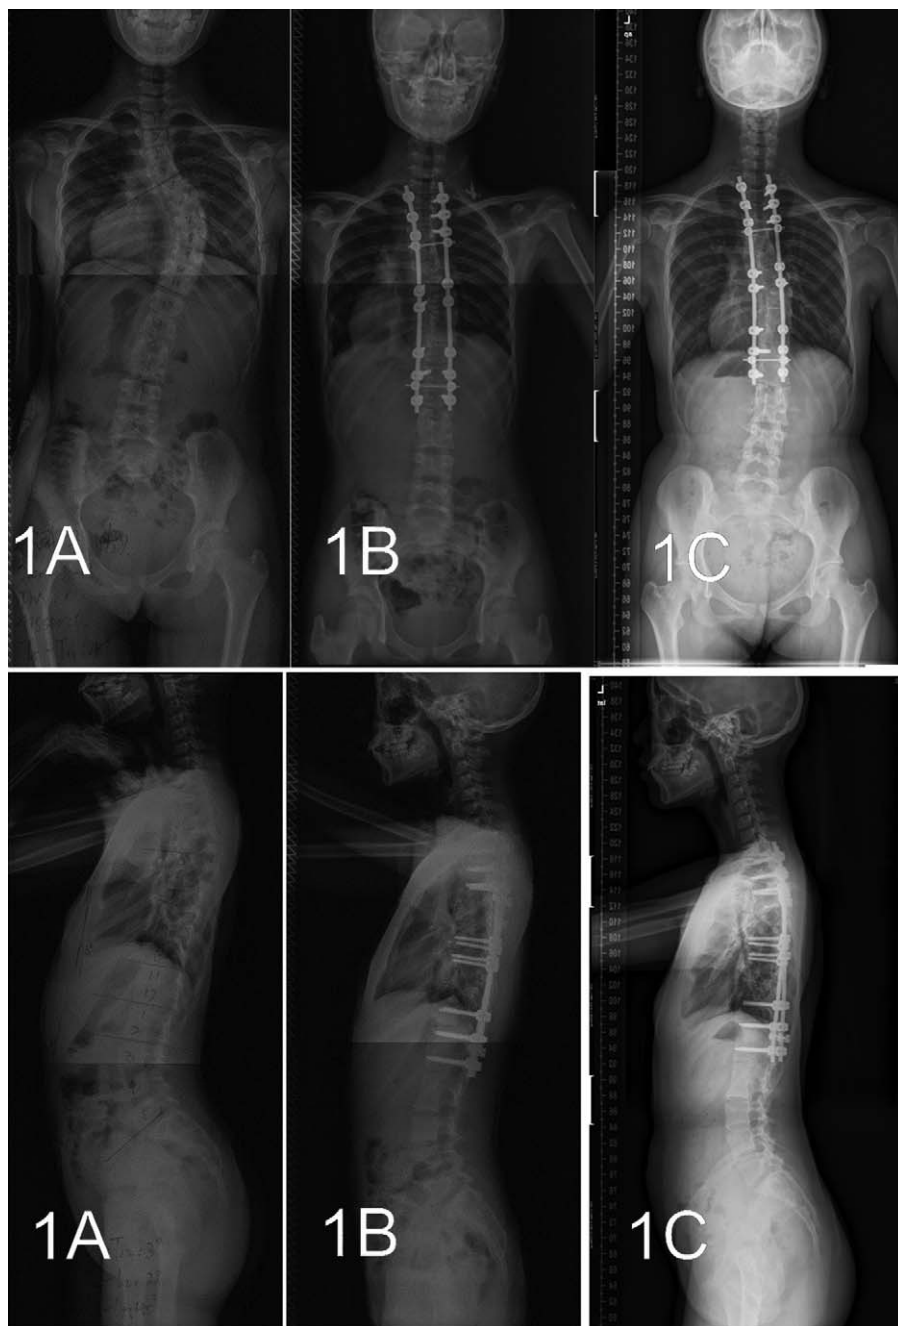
T2 was selected as the upper instrumented vertebrae, preoperative (A), immediately after surgery (B), and final follow-up (C) x-ray films.
